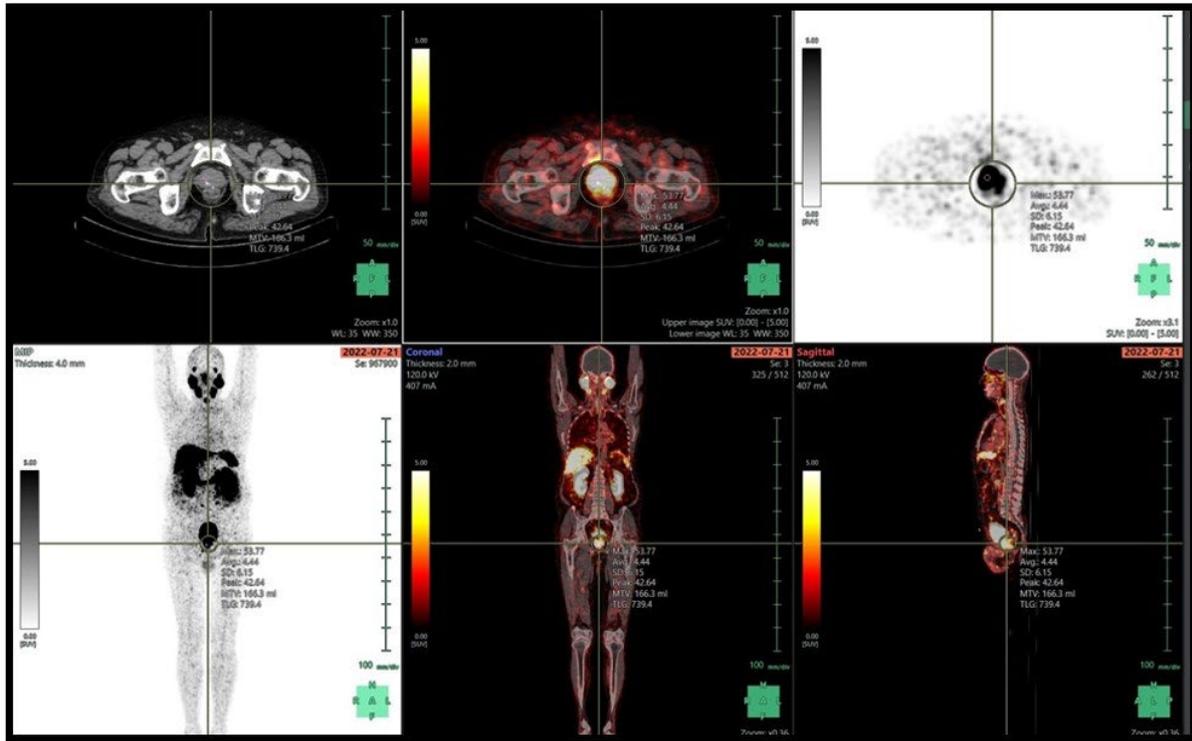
[^{68}Ga]PSMA-11 PET/CT images of 70 years old patient with carcinoma prostate, S.PSA 29.1 ng/ml, Gleason's score 8, SUVmax 53.77 and PSMA TV calculated as 166.3ml.
